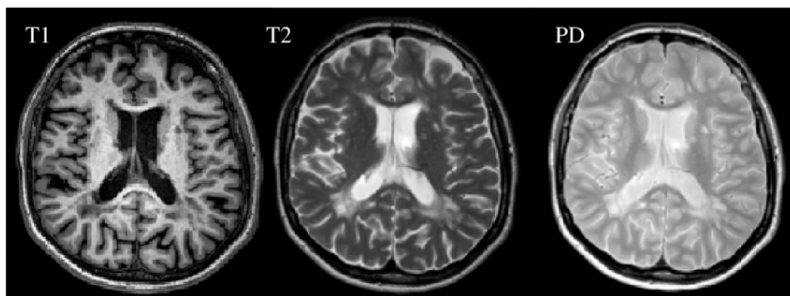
Example of three different types of contrasts T1-, T2- and PD-weighted MR images, in the transverse plane.
